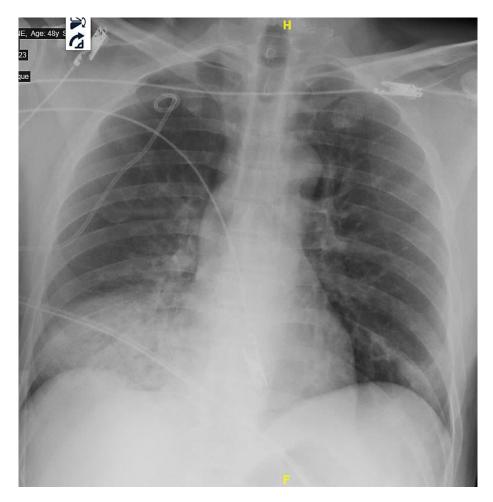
Postprocedure chest radiography
